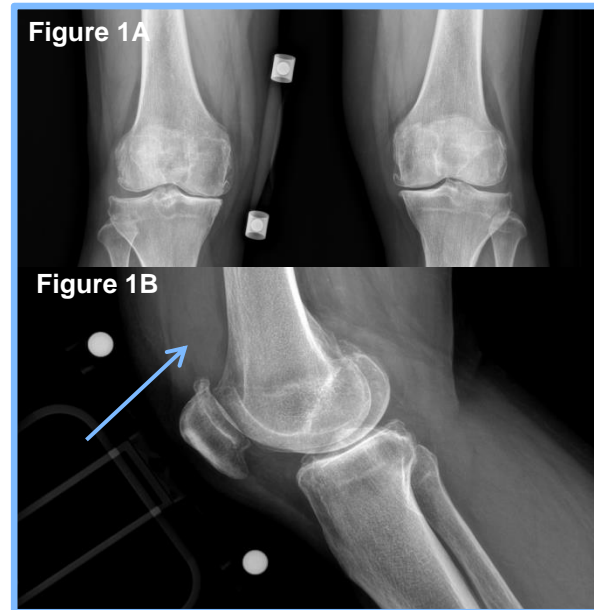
AP (A) and lateral (B) radiographs of the right knee demonstrating tricompartmental knee osteoarthritis and large joint effusion / synovitis (arrow).
